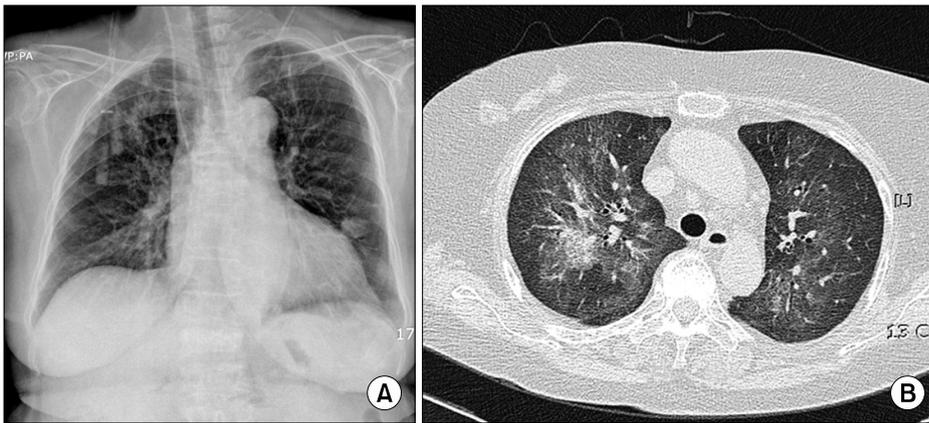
On the 12th day of admission, chest X-ray shows bilateral massive infiltrates (A). Chest CT shows diffuse ground-glass opacifications (B).
